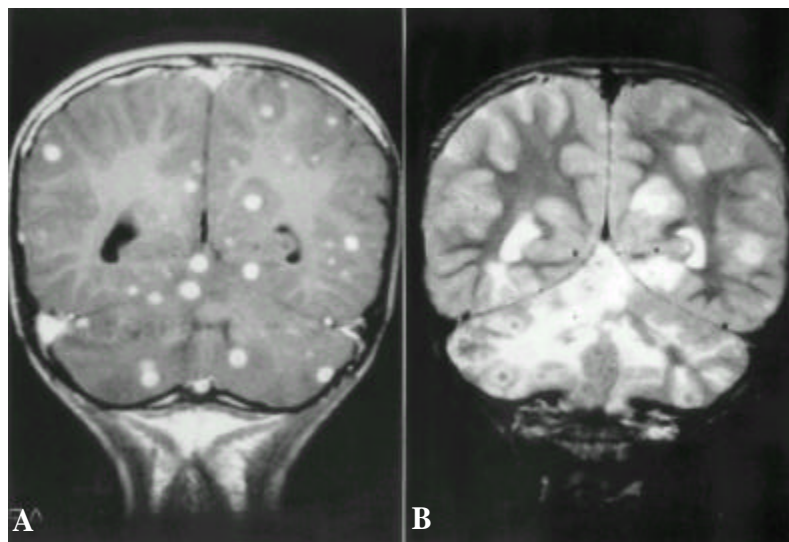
Brain MRI at admission(Coronal section). (A) Postcontrast T1 weighted image. (B) T2 weighted image. Numerous small peripheral enhancing nodules are seen in corticomedullary junction of supratentorial portion and cerebellar hemisphere. These masses show target-like appearance : central portion shows T1 high, T2 low signal intensity, and peripheral portion shows T1 iso and T2 high signal intensity.
